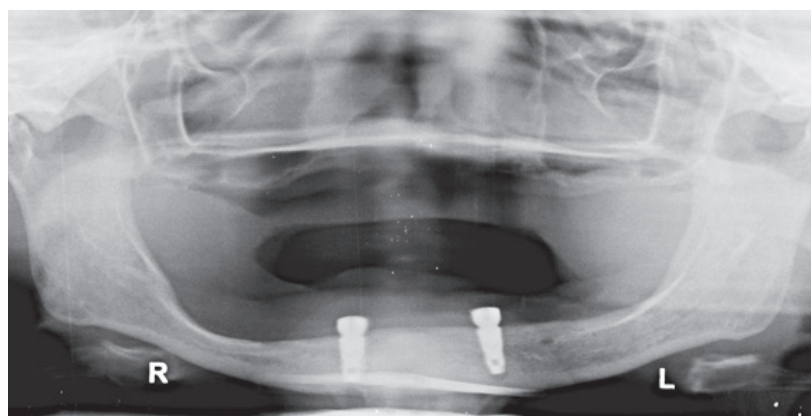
Panoramic radiograph was taken three months after implant placement.
